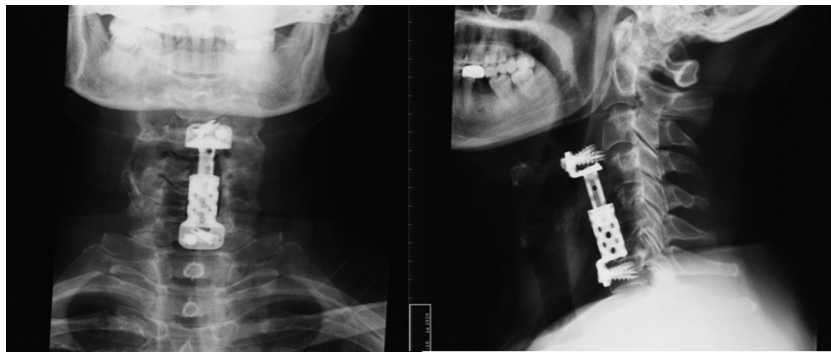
Cervical X-ray performed two days after the first operation due to dysphagia, showing: AP (left) and LL (right), the superior hardware dislocation, the pull out of the cranial screws and the removal of C4 body.
